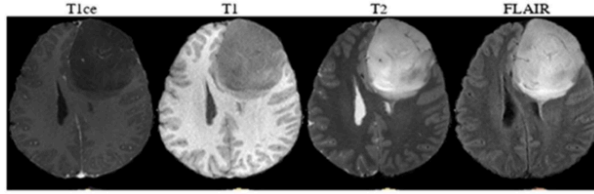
Four Sub-Files Formed (T1ce, T1, T2, and FLAIR)
